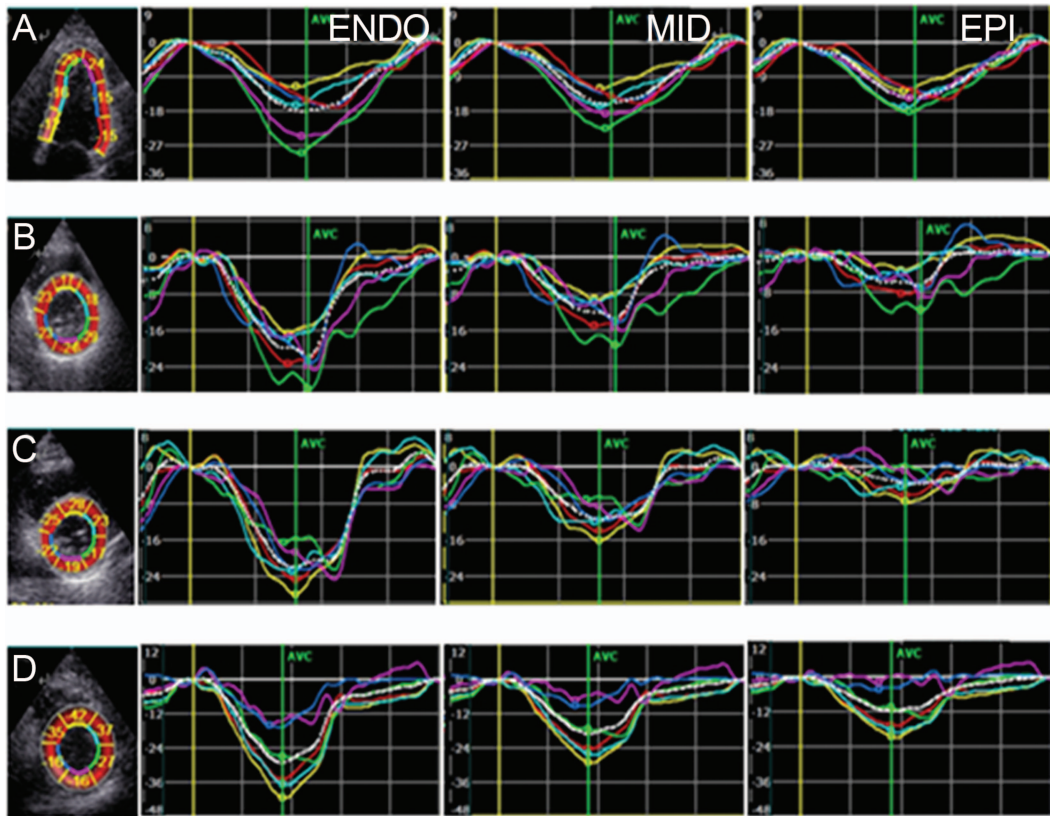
Three-layer longitudinal and circumferential strain in a subject with severe obstructive sleep apnea (apnea-hypopnea index = 62.9). A: Apical 4-chamber view, longitudinal strain. B: Short-axis view at the level of the mitral valve, circumferential strain. C: Short-axis view at the level of the papillary muscles, circumferential strain. D: Apical short-axis view, circumferential strain. Compared with control subjects, these curves show reduced amplitude in most of the segments. ENDO = endocardial strain; MID = mid-layer; EPI = epicardial strain.
